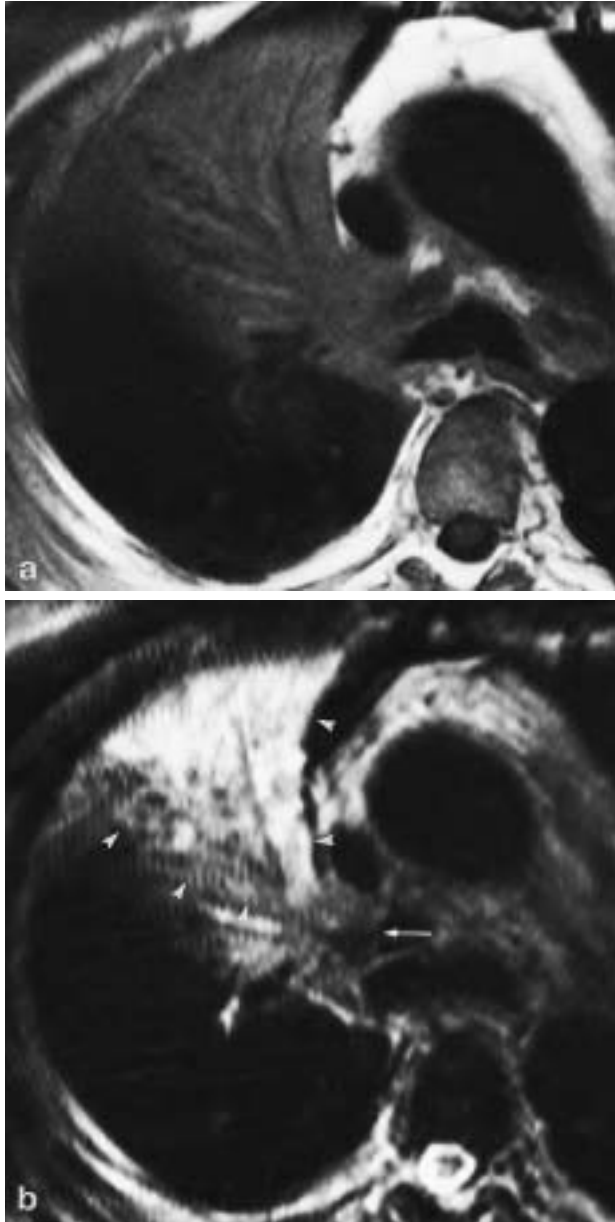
Postobstructive atelectasis. a) Unenhanced transverse T1-weighted magnetic resonance image in right central bronchogenic carcinoma, causing atelectasis of the middle lobe. There is no reliable distinction of tumour and parenchymal changes. b) Corresponding T2-weighted image with relatively low signal of centrally located tumour (arrow) and easily appreciable postobstructive atelectasis with high signal intensity (arrowheads).
